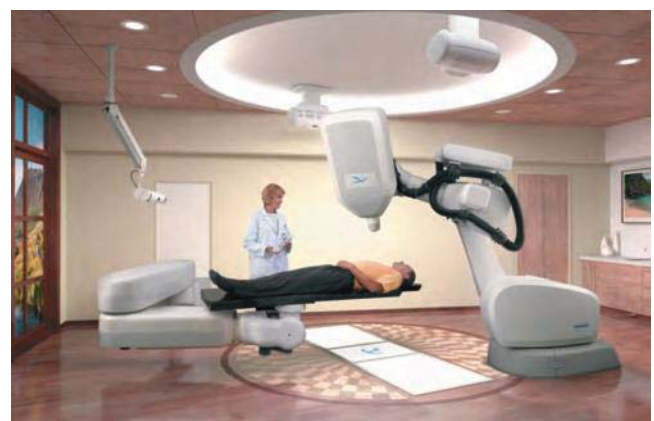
A miniature accelerator plus x-ray production system on a robotic delivery arm. Both the treatment table and the treatment head is set by a computer for multiple arbitrary angles of incidence. (From Accuray, Sunnyvale, CA, with permission.)
